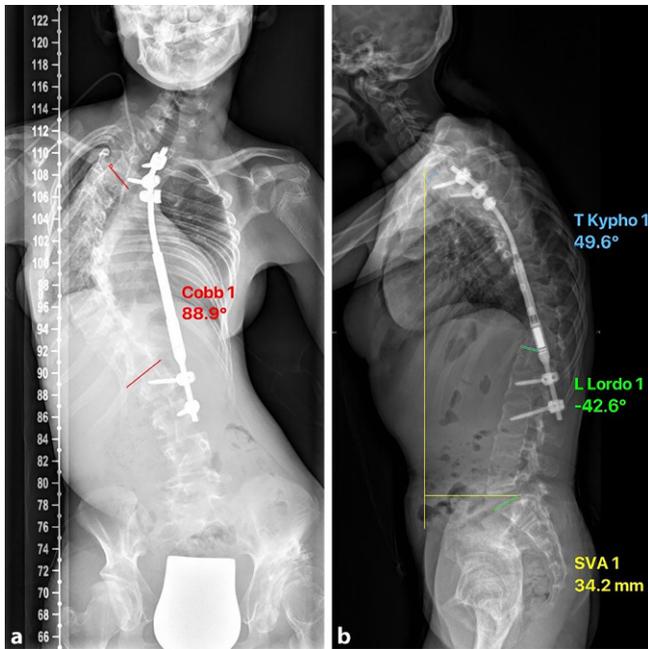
▲ Radiographs of the patient in anteroposterior (a) and lateral (b) views before initiating rod distraction. *T Kypho* thoracic kyphosis, *L Lordo* lumbar lordosis, *SVA* sagittal vertical axis
